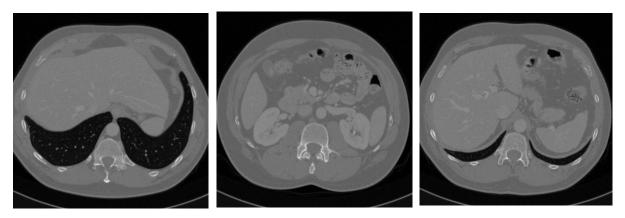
Abdominal Computed Tomography Images
